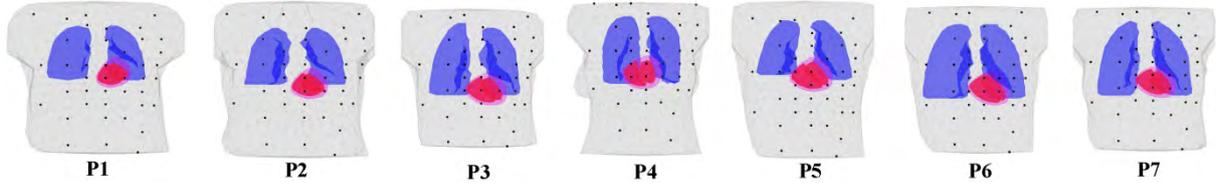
Seven realistic torso models based on MRI scans that were used in the study.
